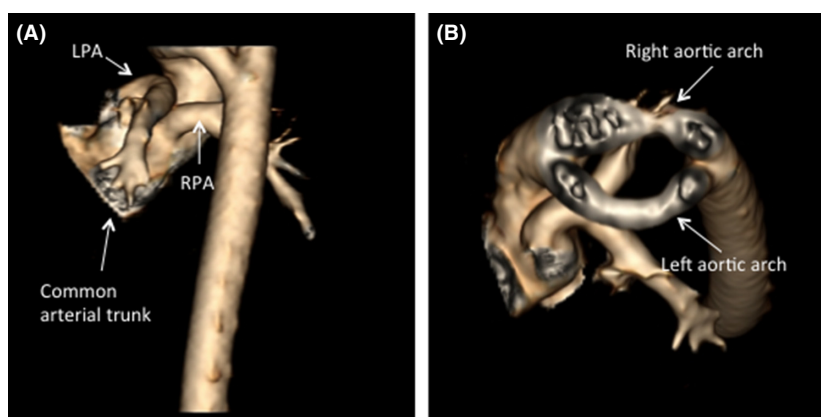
CTA-derived three-dimensional reconstruction images. (A) posterior view of common arterial trunk; (B) cranial view of right and left aortic arches forming complete vascular ring. LPA, left pulmonary artery; RPA, right pulmonary artery.
